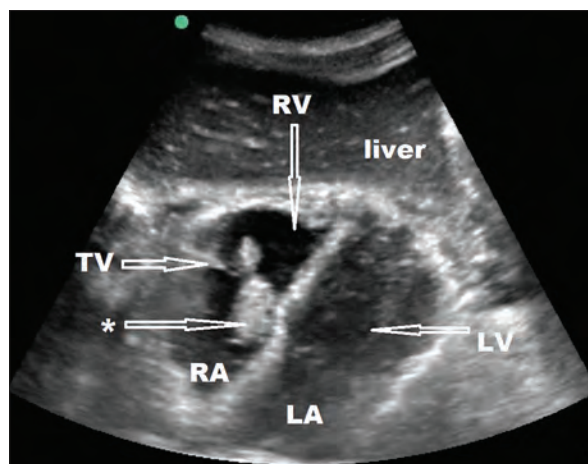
Ultrasound – subxiphoid view of the heart (*-vegetative lesion extending over both sides of the tricuspid valve, TV: Tricuspid valve, RV: Right ventricle, RA: Right atrium, LV: Left ventricle, LA: Left atrium).
